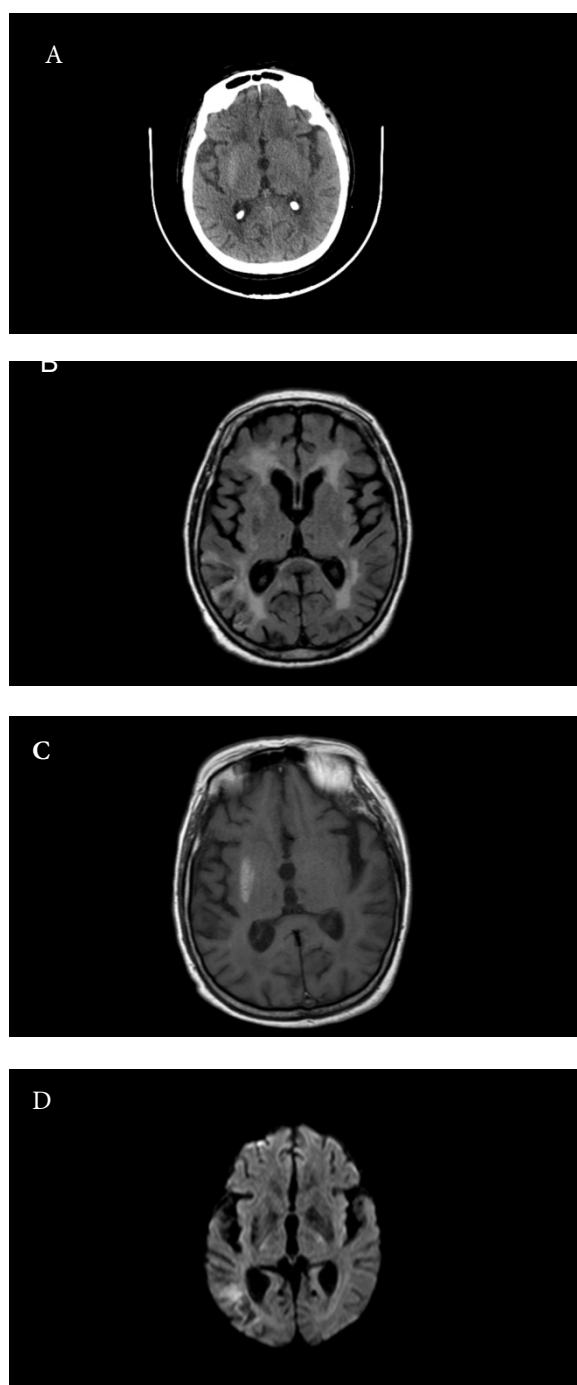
(A-D) (A) A brain CT scan revealed slight attenuation of the right putamen and globus pallidus shows with white arrow (B) FLAIR images showing hypointensities and (C) T1 weighted images with white arrow shows hyperintensities in the right lenticular nucleus (D) Diffusion Weighted MR image demonstrating no diffusion restriction.
